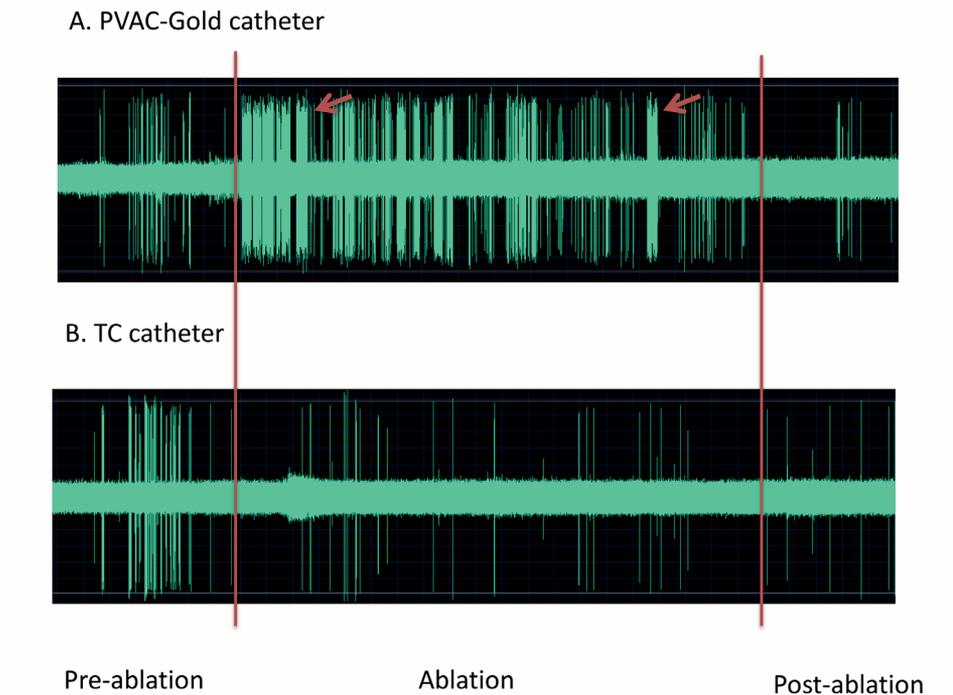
Example of transcranial Doppler recordings.
